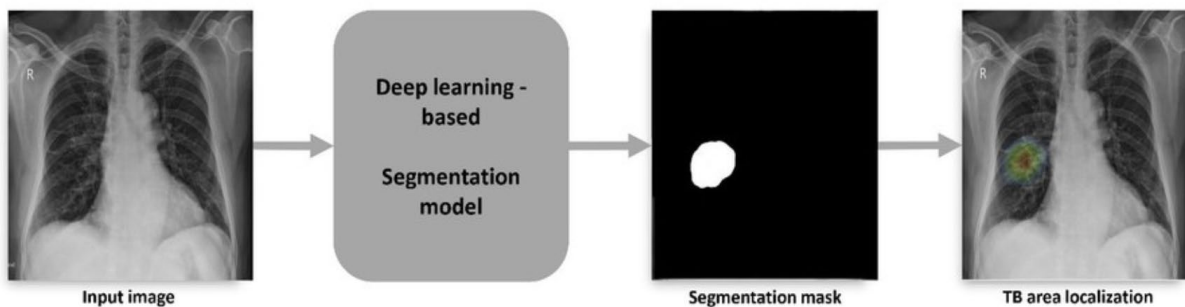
Utilizing AI in reading Chest X-rays for TB screening in Vietnam (VinBrain and FIT Utilizing AI in Tuberculosis Screening in Vietnam, n.d.)
